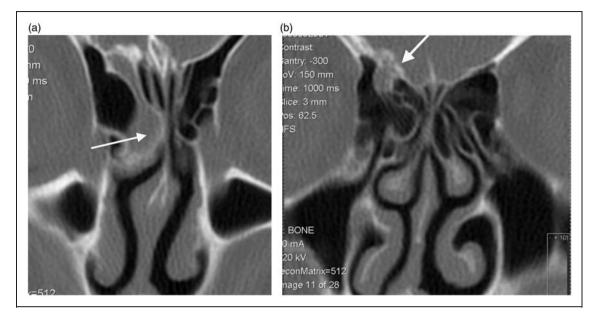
(a) Coronal CT sinus scan and (b) Sagittal CT Sinus scan; 4mm wide bone defect in the anterior cribriform plate just to the right of crista galli, with a small meningoencephalocoele sac as confirmed at surgery. (c) Axial post gadolinium T1W scan showing a small meningocoele in the right anterosuperior nasal cavity with central fluid signal and rim enhancement of adjacent mucosa.
